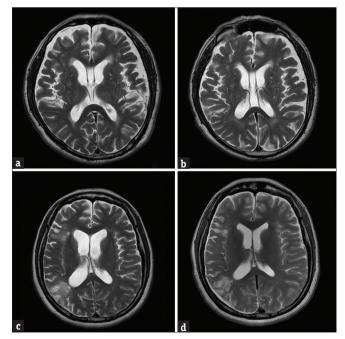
The brain magnetic resonance imaging before the shunt surgery revealed ventriculomegaly. (a and c) The ratio of FH/ID was 0.316 in case one and 0.346 in case two. The FH/ID (FH: Largest width of frontal horns; ID: Internal diameter from inner table of skull to inner table at this level) ratio decreased after surgery, 0.301 in case one and 0.305 in case two respectively. (b and d) Both of the two cases got obvious decreased ventricle size, and postoperative magnetic resonance imaging also revealed remission of periventricular lucency
